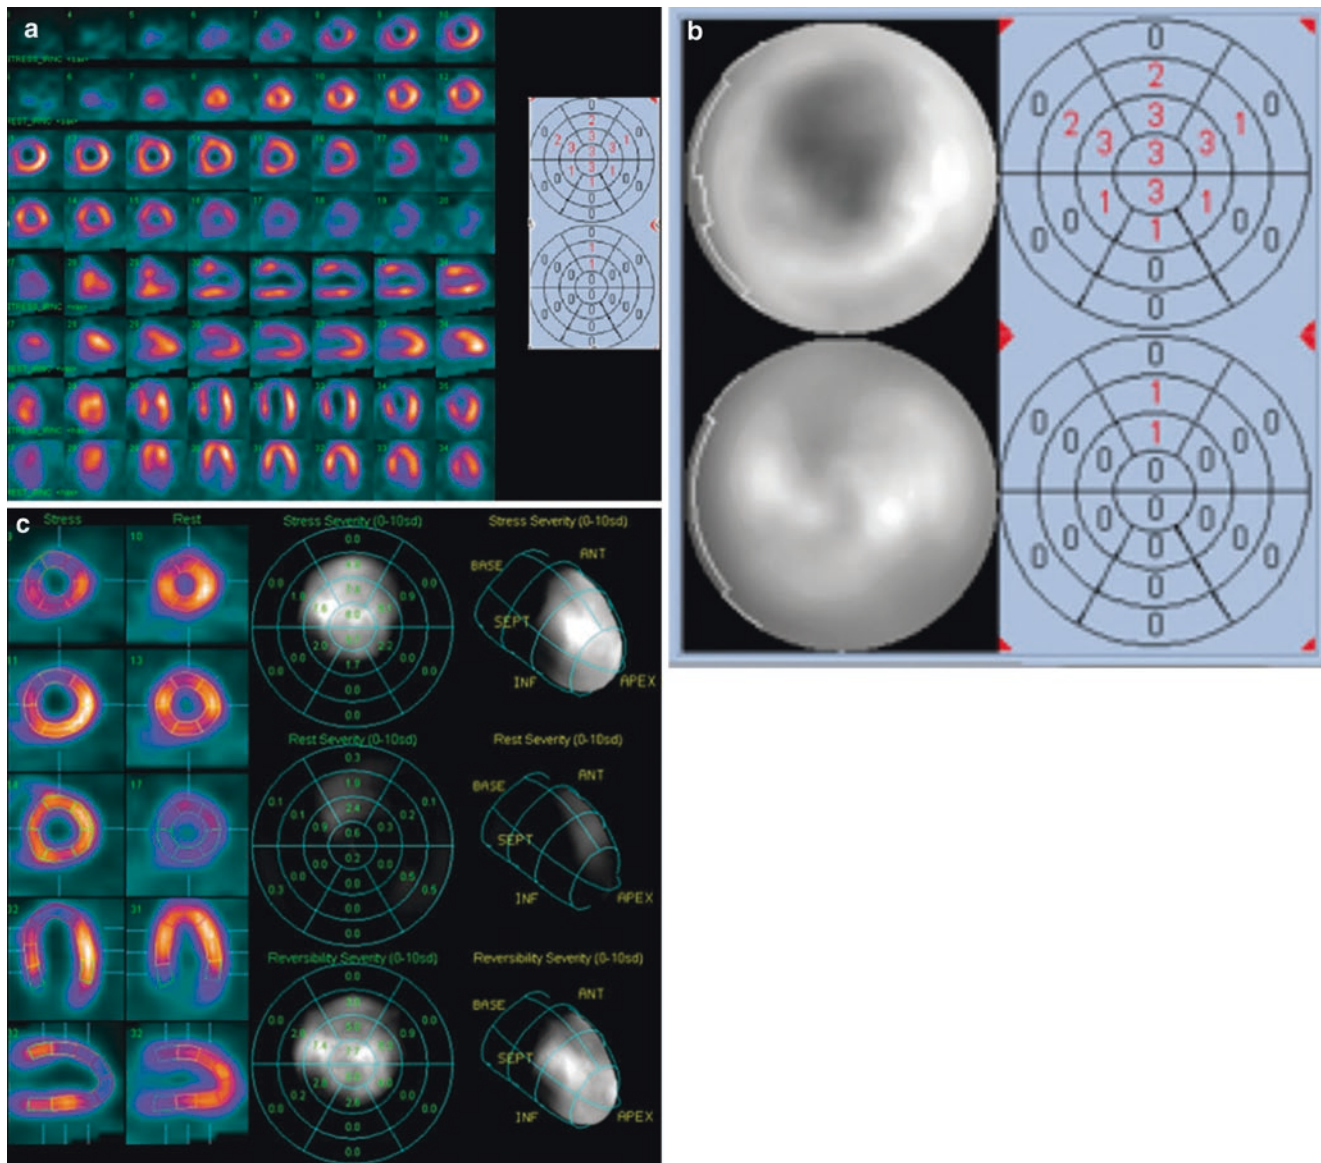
Gated stress perfusion imaging. (a) Shown in the *top row* and continuing in the *third row*, from apex (*left*) to base (*right*), are color-coded SPECT stress perfusion images in a 49-year-old man with atypical chest pain and an equivocal stress test result. Images were performed with the dual-isotope ^{201}Tl rest, $^{99\text{m}}\text{Tc}$ stress protocol. In the *second* and *fourth rows* are the rest images in the same patient, acquired at baseline. Below these images, in alternating rows from top down, are stress and rest images in the same patient presented in vertical long axis, *left to right*, from the septum to the lateral wall, and the horizontal long axis, *left to right*, from the inferior to the anterior walls. Cavitory dilatation with a gross, reversible, apical, anterior, and septal defect is evident, consistent with significant flow-limiting disease in the left anterior descending coronary artery. The summed stress score of 20 confirms the high related coronary risk. (b) Shown is the quantitative perfusion SPECT or quantitative perfusion AutoQuant (Cedars Sinai Hospital, Los Angeles, CA) display, with the *left panel* showing segmented stress
